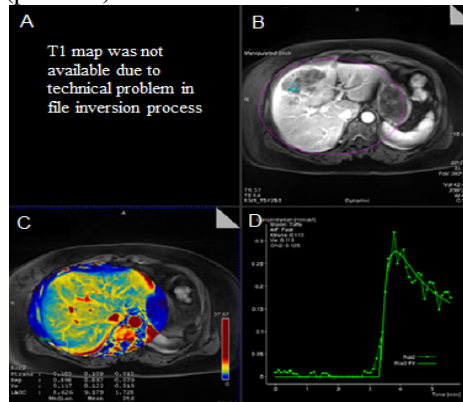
DCE-MRI : Radial-VIBE
